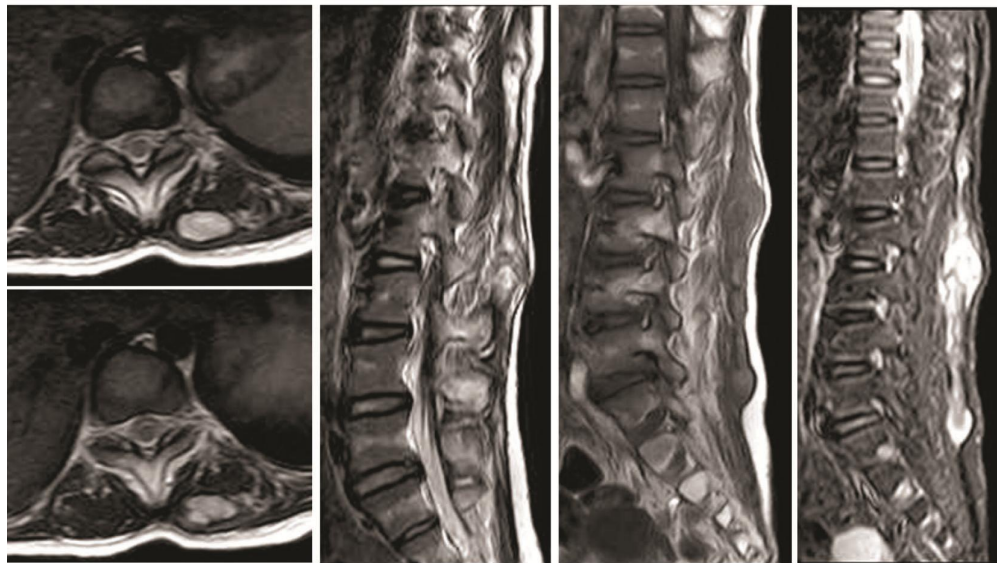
MRI of thoracolumbar shows paravertebral ossification
